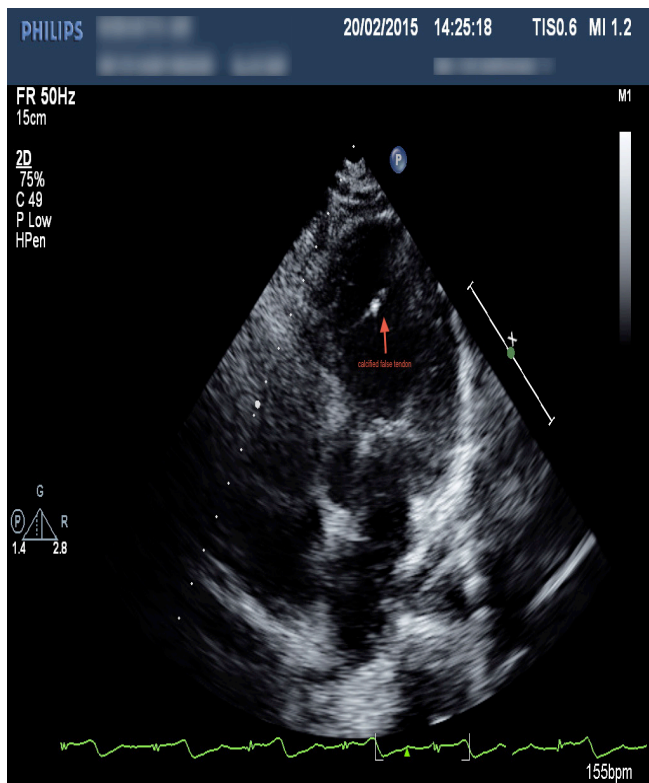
Apical 4chamberview Showing Calcified False Tendon
